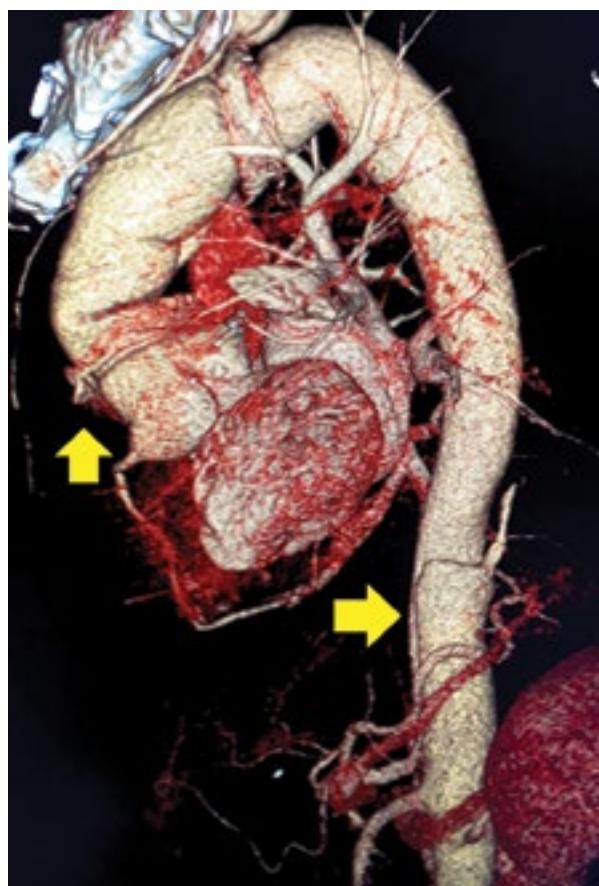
Rendered three-dimensional computed tomography (3D CT) scan: no leakage signs within the prosthesis
